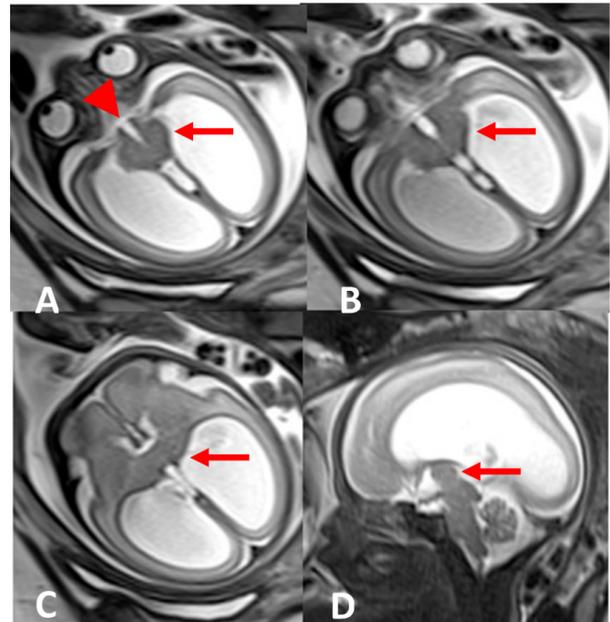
In uterine T2 MRI sequences of a male fetus at 26 weeks of gestation in axial (A, B, C) and sagittal plane. Imaging shows an abnormal midbrain contour with thick cerebral pedicles (arrows in A and B) and a mild midline cleft that is not as deep as the classic pathognomonic butterfly-like sign (arrowhead in A). The mild midline cleft is continuous with the third ventricle (A and B). Superiorly, the thalami are fused in the midline (arrow in C). The interthalamic adhesion is thickened and poorly defined (arrow in D), and there is a complete continuity between the thalami/ interthalamic adhesion and the midbrain (D), characterizing DMJD type C. There is aqueduct stenosis and severe hydrocephalus with thinning of the supratentorial brain on the sagittal plane (A-D). No other associated abnormality was found in the posterior fossa, globes, or orbits. No malformation of cortical development was seen in this case.
